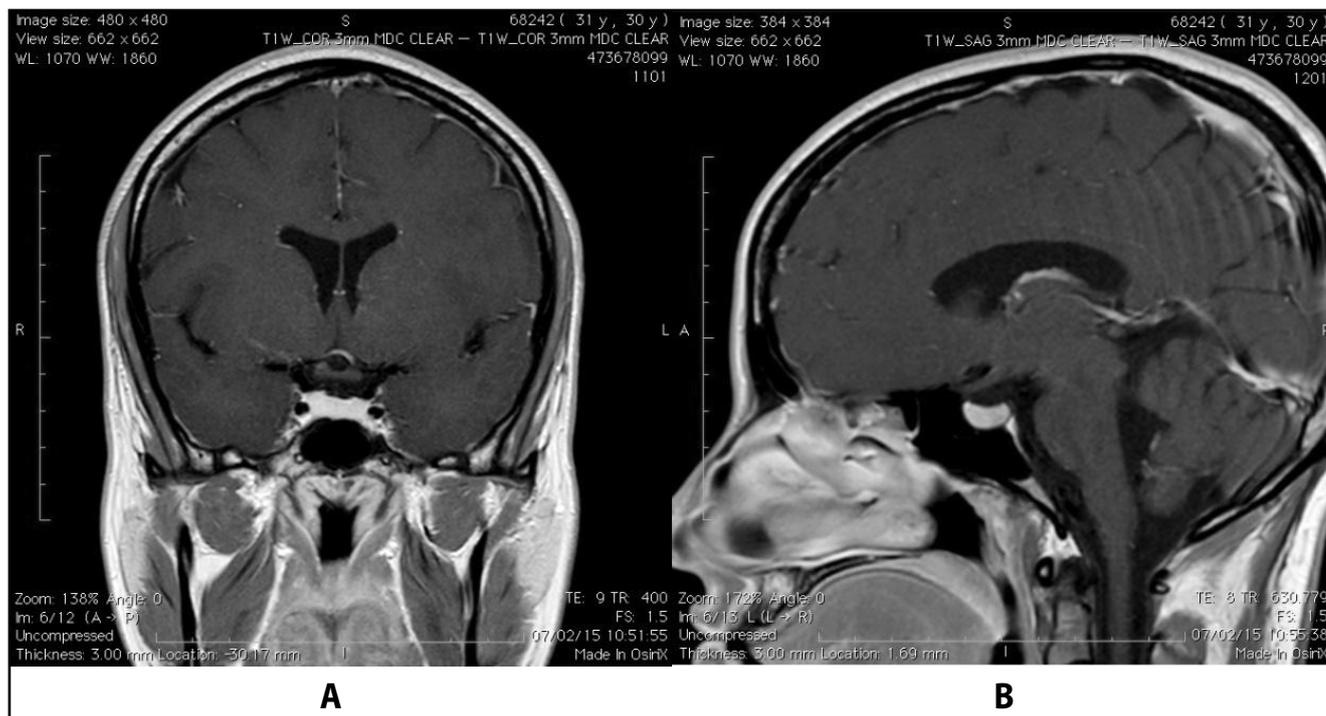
Pituitary Gd-DTPA enhanced MRI 6 months after the modification of thyroid hormone replacement showing significant reduction of pituitary size. (A) enhanced coronal image. (B) enhanced sagittal image.
